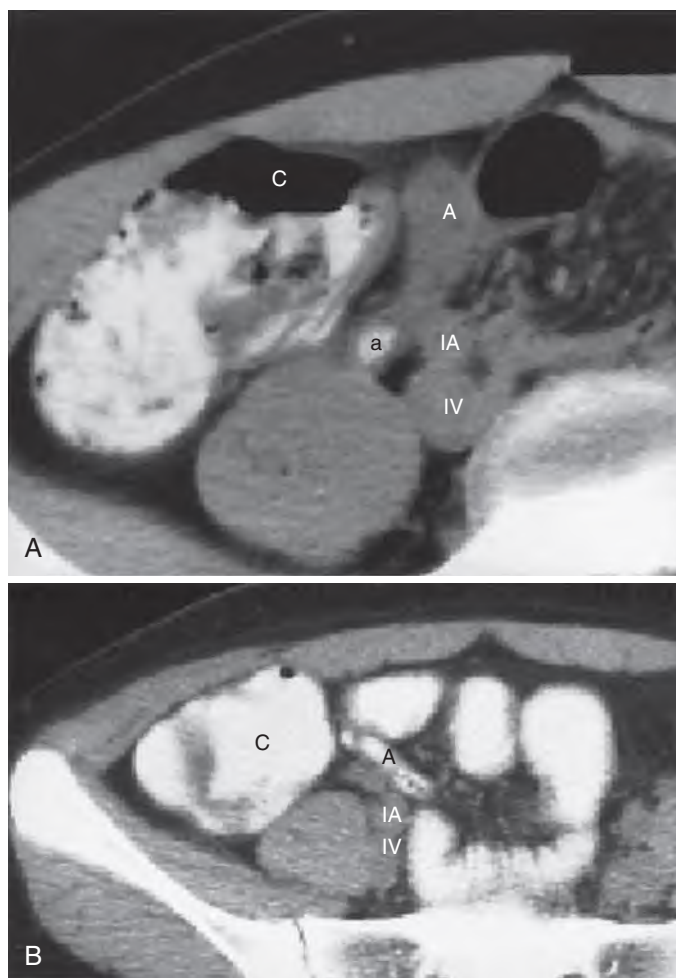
Appendicitis. (A) Computed tomography (CT) scan of a 17-year-old boy with appendicitis. Axial image shows an inflamed, unopacified appendix (A), 15 mm in diameter, with proximal appendicolith (a). Also shown, and also in part B, are the cecum (C), common iliac artery (IA), and common iliac vein (IV). (B) CT scan of a 21-year-old woman with appendicitis. Axial image shows a tubular, opacified normal appendix (A). (From Rao PM, Rhea JT, Novelline RA, et al. *Effect of computed tomography of the appendix on treatment of patients and use of hospital resources.* N Engl J Med. 1998;338:141–146. Copyright © 1998 Massachusetts Medical Society. All rights reserved.)
